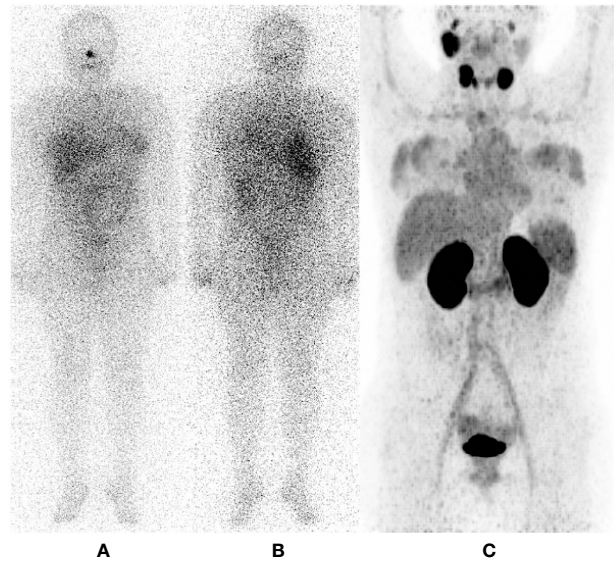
73 years old female treated with total thyroidectomy + RAI (cumulative dose 14800 MBq); Thyroglobulin 546 ng/ml. (A, B) ^{121}I – post therapy whole body scan shows no uptake other than usual biodistribution. Physiological uptake variant was observed in mammary glands with both tracers. (C) ^{68}Ga – PSMA PET/CT MIP, on the other hand, conspicuously shows a central cervical compartment adenopathy.
